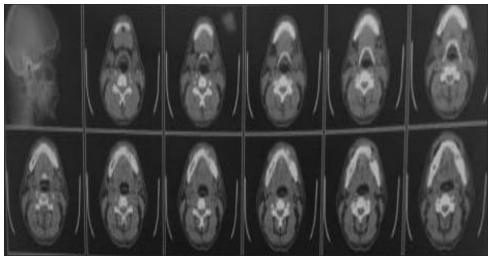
CT Scan showing involvement of buccal plate and thinning out of lingual plate of mandible over left side
